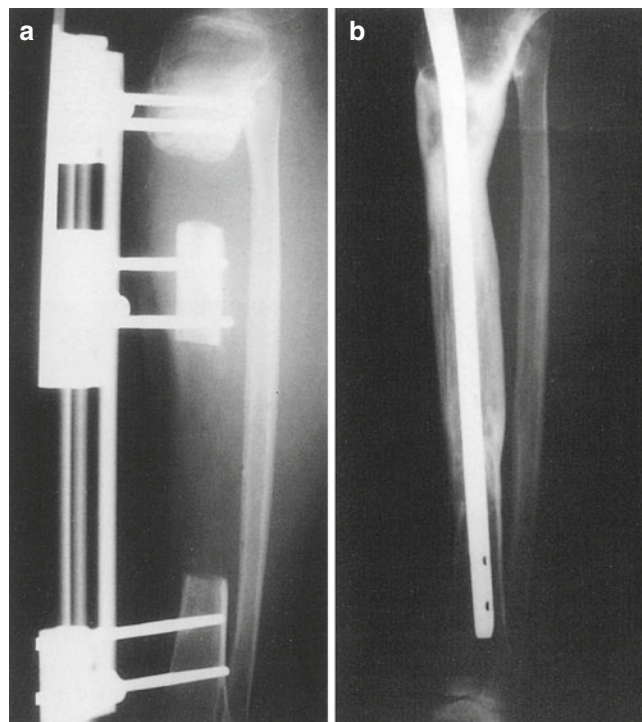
(a) Initial radiograph following bone transportation of the tibial diaphysis. (b) Final radiograph following bone transportation of the tibial diaphysis
